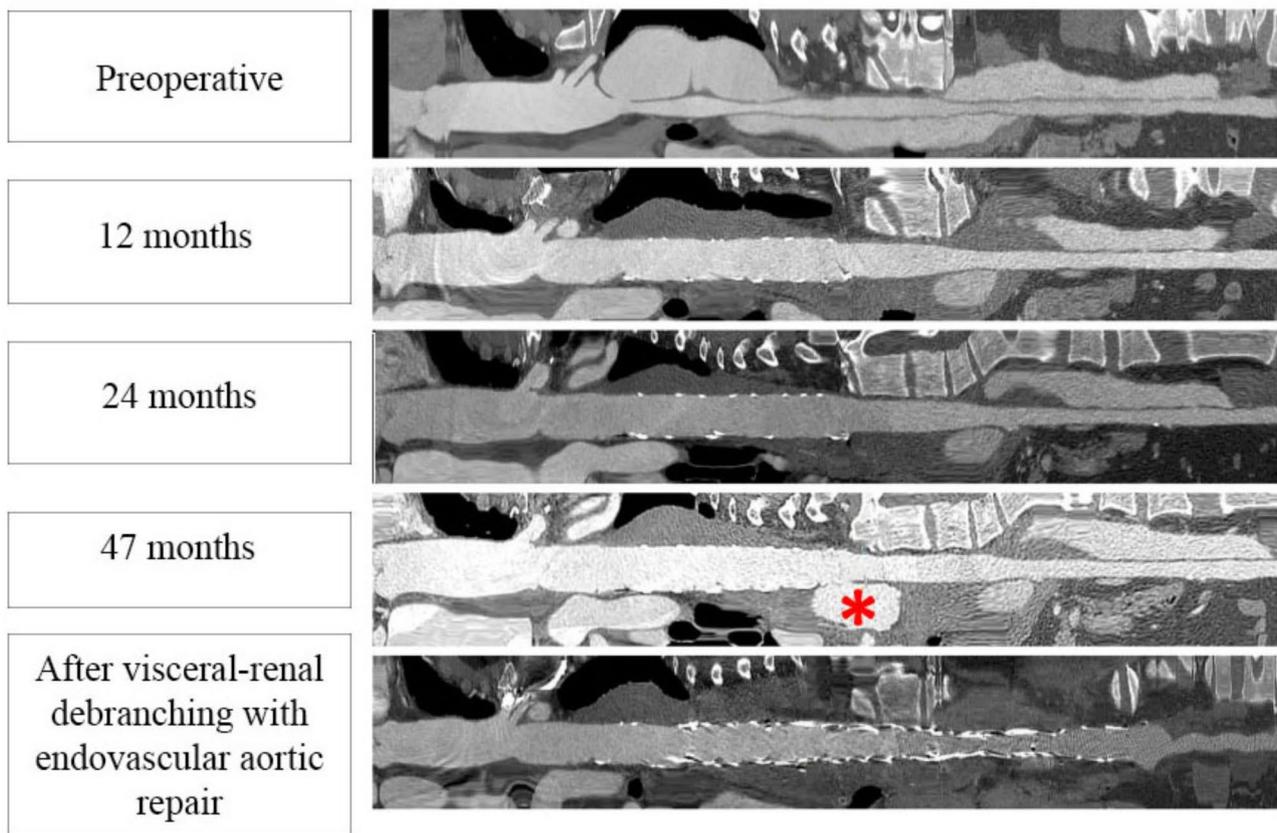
Three-dimension reconstruction CT scans of the thoracoabdominal aorta. First line
